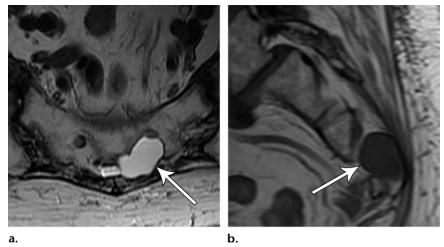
Cystic mass in a 78-year-old woman with coccydynia. Axial T2-weighted (a) and sagittal T1-weighted (b) images show a cystic mass (arrow) associated with the S2 nerve root (perineural or Tarlov cyst) that has caused enlargement of the left lateral aspect of the sacral canal and left S2 foramen. It is uncertain if this was related to the coccydynia.
